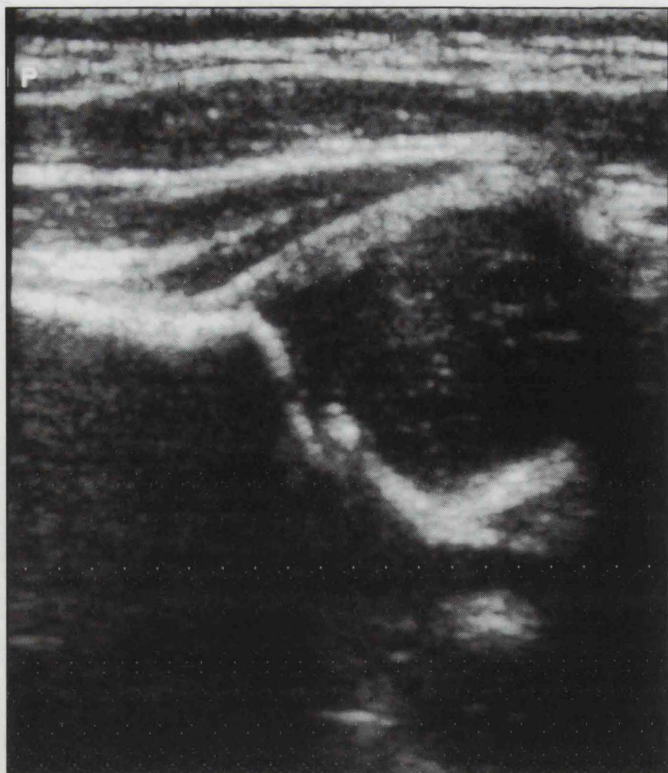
Ultrasound examination of a normal hip. Note that the circular femoral head lies within the 'wineglass' acetabulum
